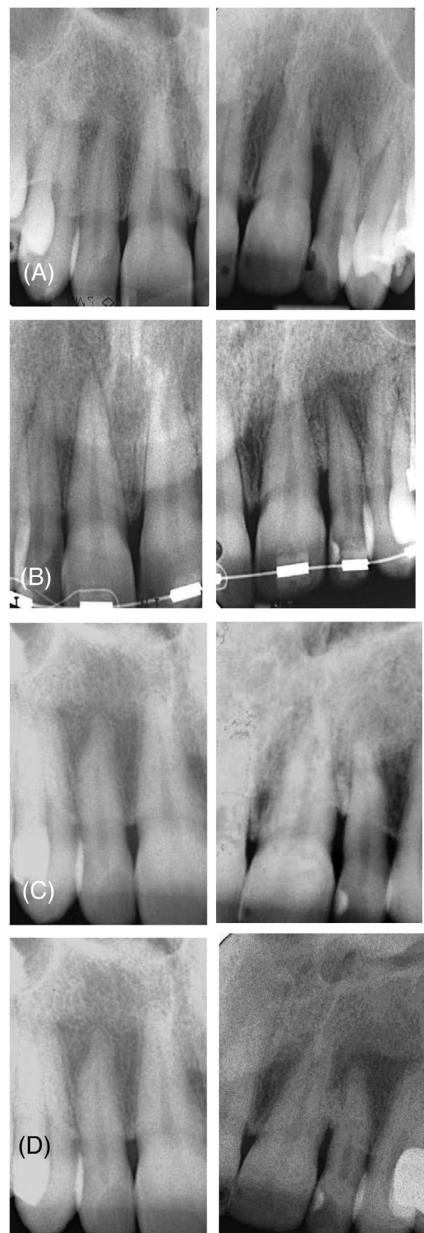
(A–D): Radiographical situation of 48-year-old patient diagnosed with stage IV periodontitis (A) after step 1 and 2 of periodontal therapy (T0 = baseline), (B) 1 year after regenerative therapy (T1), (C) at final splinting (T2), (D) 10 years after regenerative therapy (T10).
